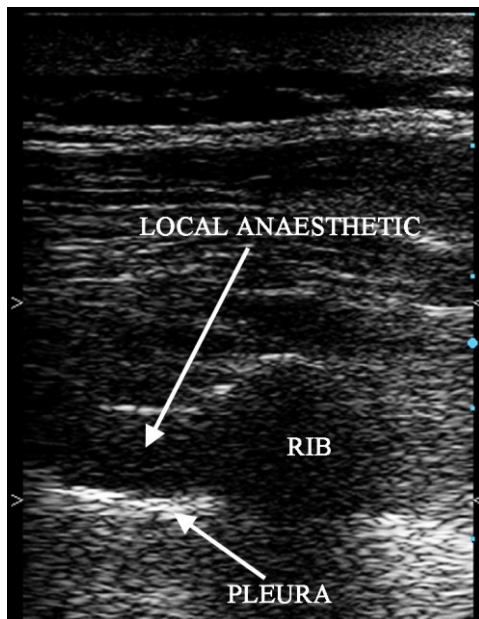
sonogram of paravertebral block after injection of local anaesthetic
